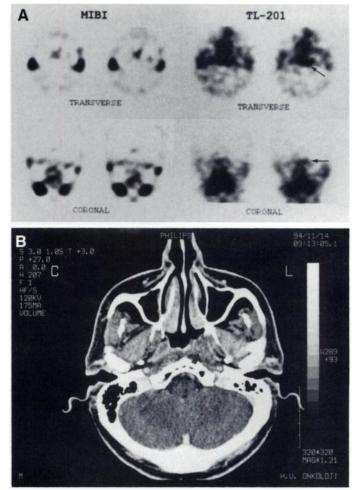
(A) Transverse slices (arrows, upper panel) and coronal slices (arrows, lower panel) of MIBI SPECT head and neck study, do not demonstrate any area of abnormal radiotracer uptake in the nasopharynx. However, the <sup>201</sup>TI SPECT study shows a focus of increased radiotracer uptake in the nasopharynx extending towards the right pharyngeal nasopharynx (arrows). (B) CT study of the nasopharynx performed 4 mo after completion of therapy shows a residual mass in the nasopharynx (arrow) interpreted as residual/ recurrent NPC, but biopsy of the corresponding region revealed chronic inflammatory changes with no evidence of residual carcinoma. Ten-month clinical follow-up data confirmed biopsy findings rendering <sup>201</sup>TI and CT results false-positive.
